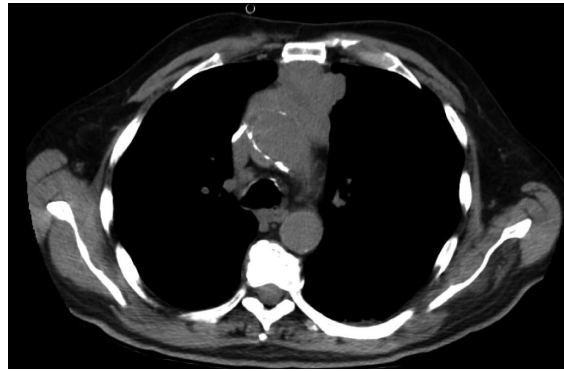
Computed tomography thoracic scan showing an anterior mediastinal mass with lobular contours measuring 60 mm × 66 mm.
